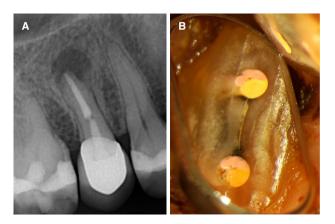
A narrow long isthmus as a cause for endodontic failure. (A) Radiograph of a right second maxillary premolar revealing a failing endodontic case, in spite of apparently adequate root canal filling. (B) The cause of failure: a long narrow isthmus. Adapted from Metzger et al. (75).
